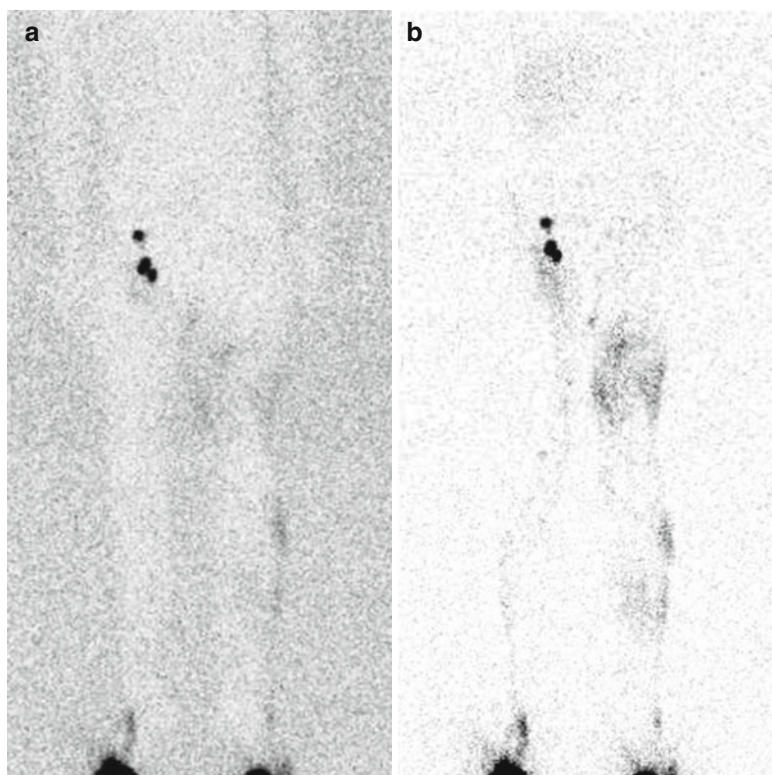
Abnormal lymphatic function demonstrated by lymphoscintigraphy. (a) In a 7-year-old boy with left lower extremity edema, lymphoscintigraphy is performed after intradermal injection of filtered ^{99m}Tc -labeled sulfur colloid in the dorsum of each foot. After 50 min, tracer accumulation in numerous pelvic lymph nodes demonstrates normal lymphatic transit in the right leg. In the left leg, abnormal lymphatic transit is demonstrated by the absence of tracer accumulation in pelvic lymph nodes. Cutaneous accumulation of tracer (dermal backflow) also
